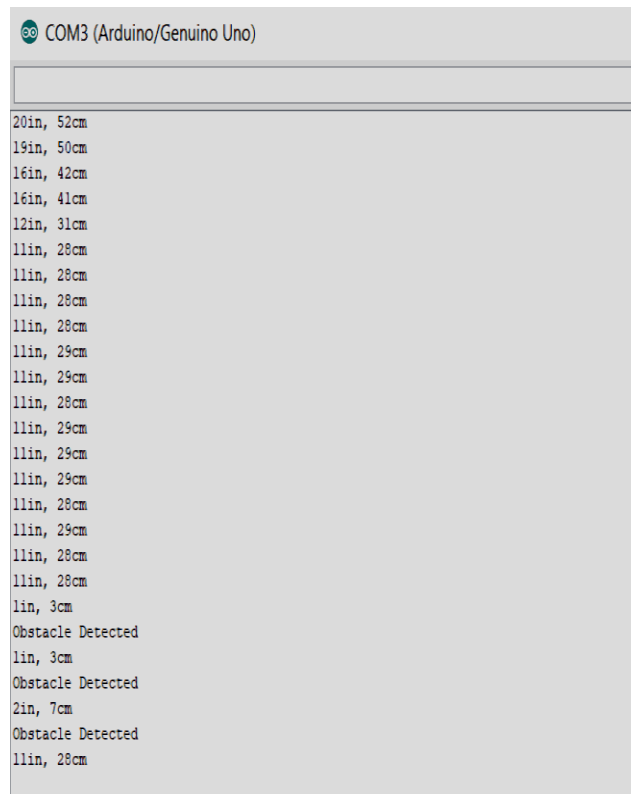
Ultrasonic sensor readings
